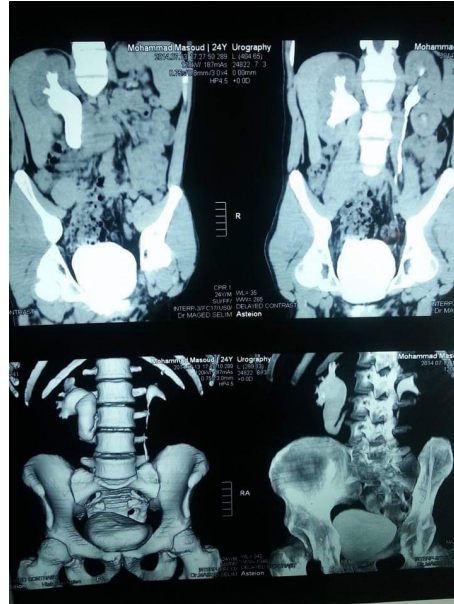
CT scan with IV contrast of Case 1 revealed a dilated right renal pelvicalyceal system and upper ureter with the fish-hook sign.
